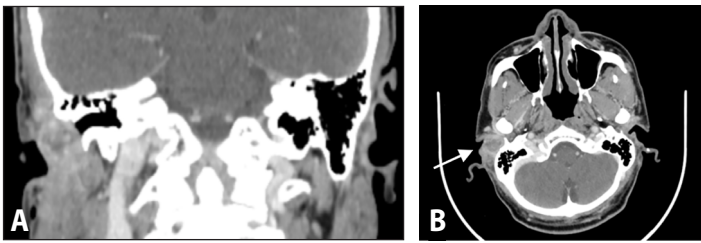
Contrast enhanced temporal bone computed tomography scans A. Coronal cut at the level of the external auditory canal; and B. Axial cut at the level of the maxillary sinus showing a 2 x 1.9 cm mixed density soft tissue focus (white arrow) in the right external auditory canal
